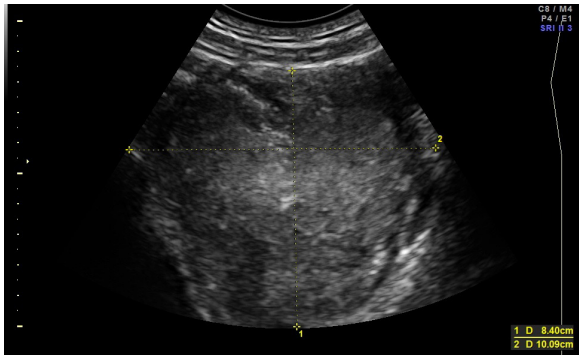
Transabdominal ultrasound image of 10 cm purely solid benign Brenner tumor
